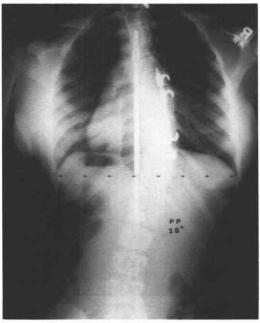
X-ray showing Harrington rod system.
